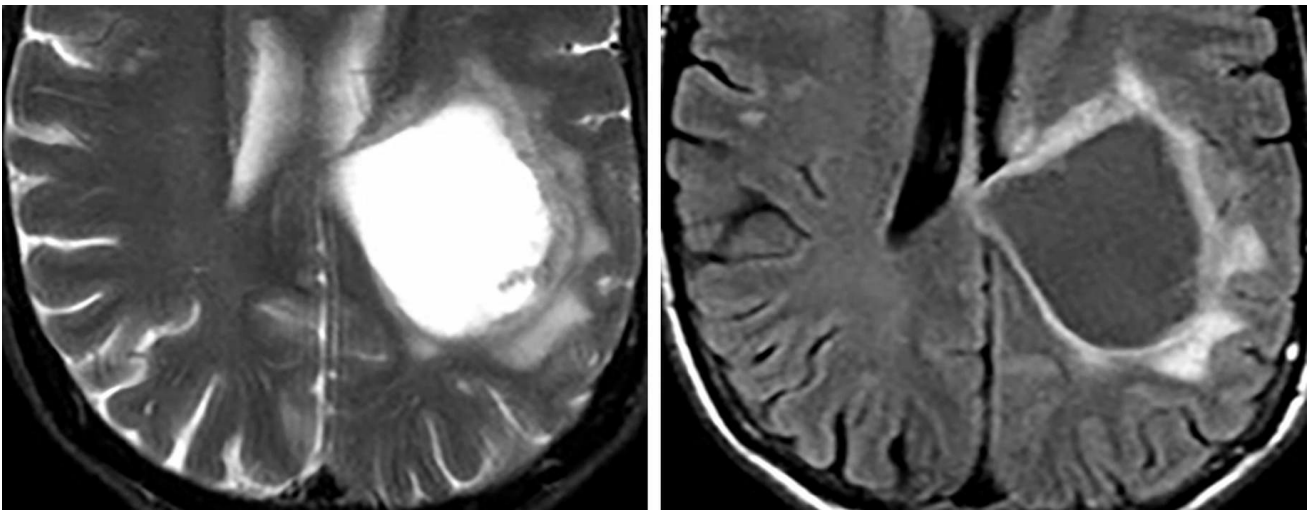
These images demonstrate a fairly classic appearance of parenchymal blastomycosis. There is a large, cystic lesion with smooth rim enhancement demonstrated before and after contrast (Top Row), normal diffusivity in the cavity on DWI/ADC (Middle Row), and a mild amount of surrounding vasogenic edema on T2/FLAIR imaging (Bottom Row). More commonly, these patients will present with meningitis (not presented here).
